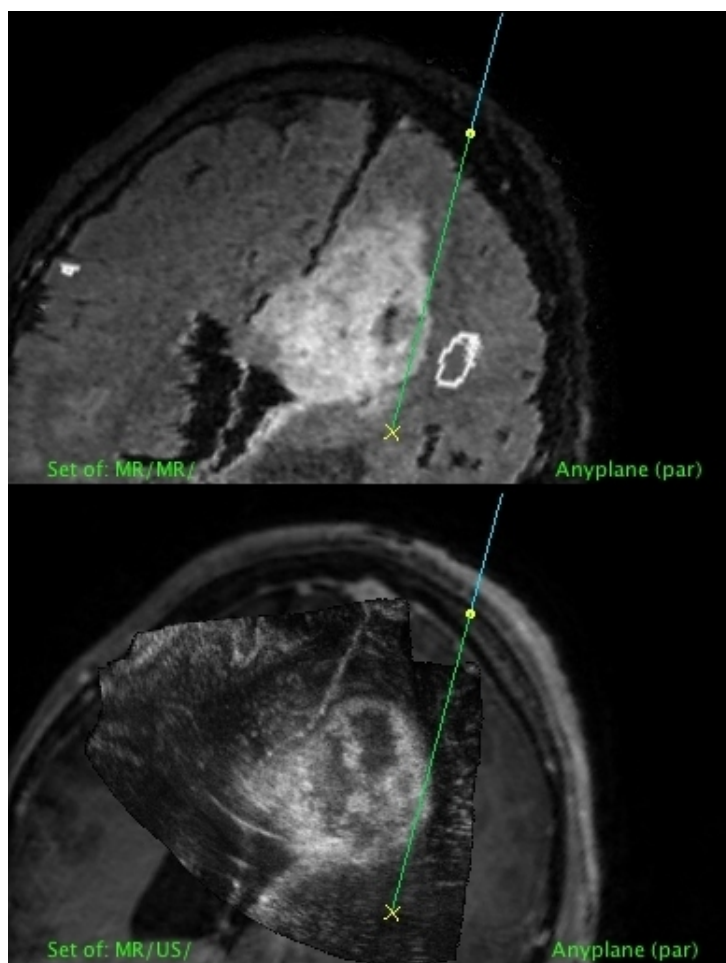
Screenshot from the SonoWand system. The upper image shows the preoperative MR scan, while the lower image shows intraoperative US superimposed on the MR image.
